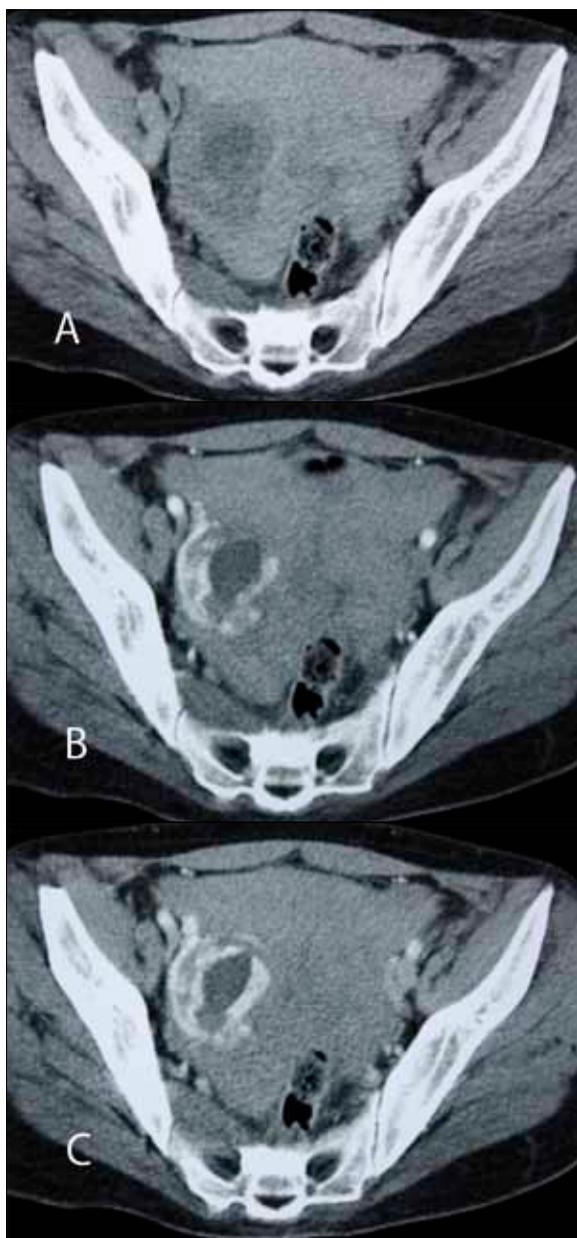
(A) Non-contrast axial CT scan with hemoperitoneum. Axial CT scan after i.v. contrast administration revealing a pathological solid-cystic mass with a strong, peripheral enhancement in arterial (B) and venous (C) phases.
